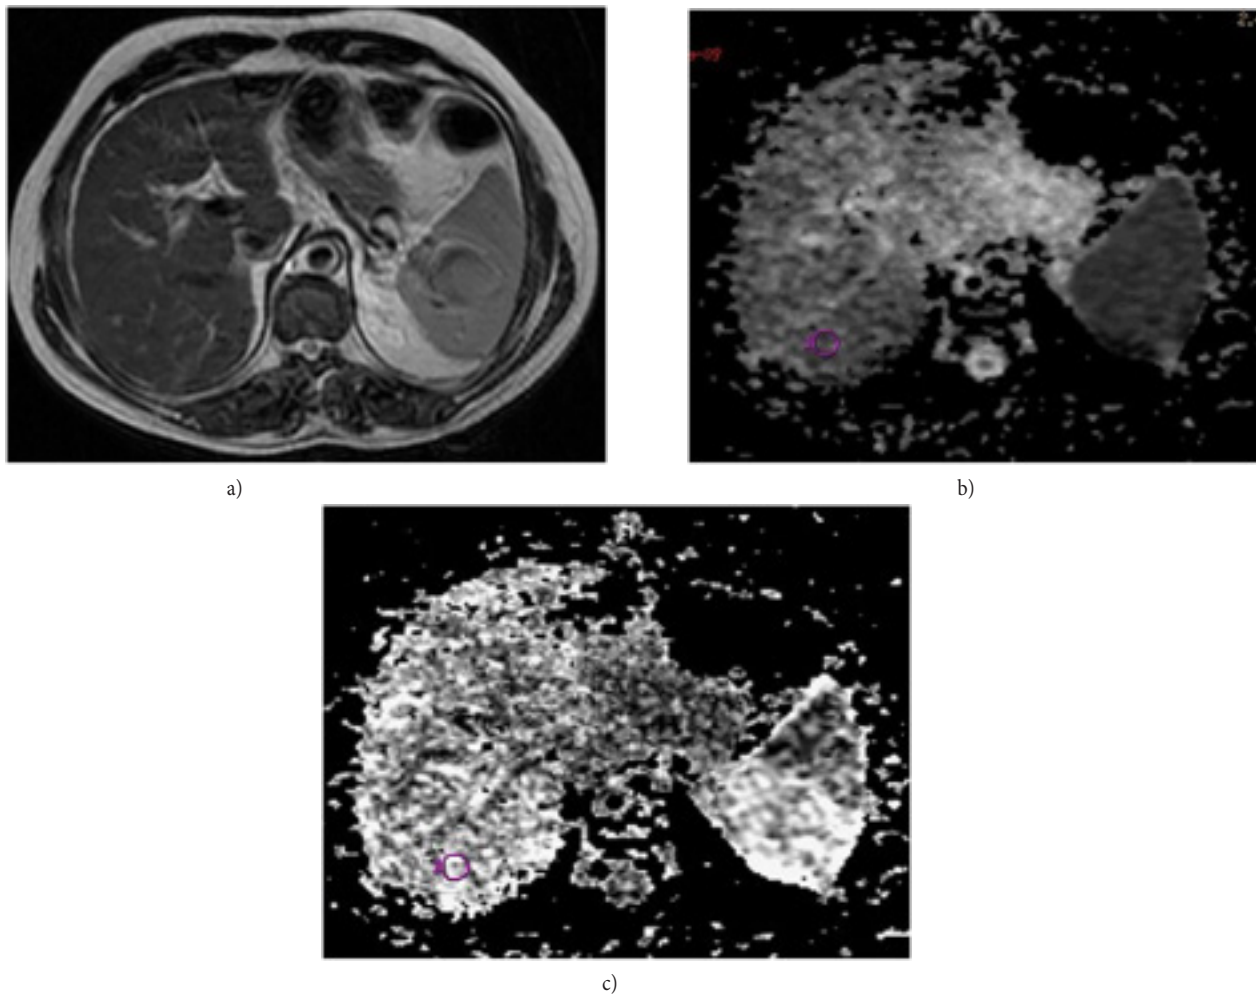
T2-weighted image (a), ADC map (b) and Fa map (c) of a patient with score 3 fibrosis. His HAI score was 10.
